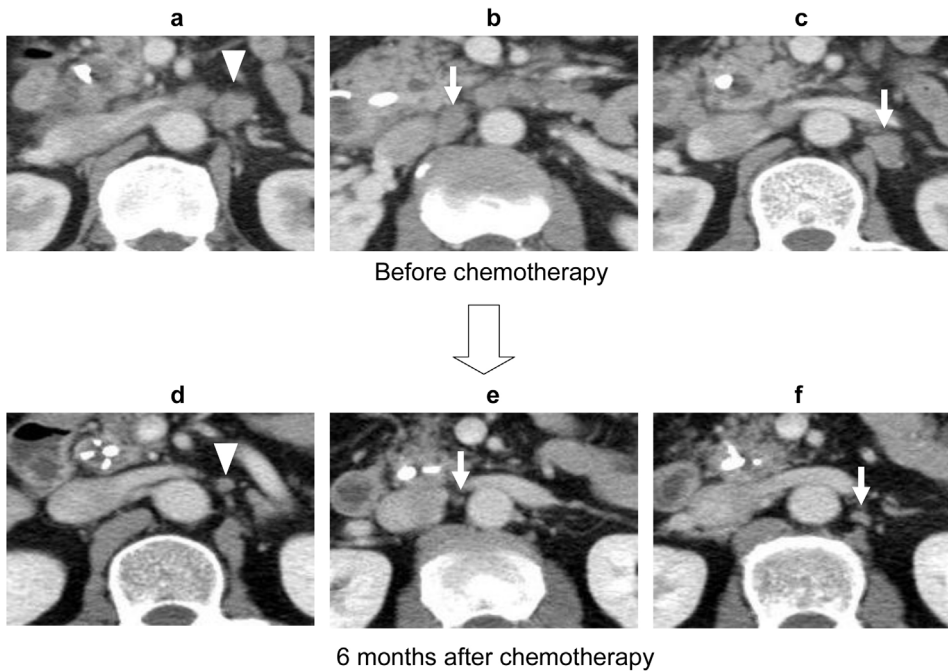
CT scans show reduction of lymph nodes #16a2 (arrow heads) (a,d) and #16b1 (arrows) (b,c,e,f).
